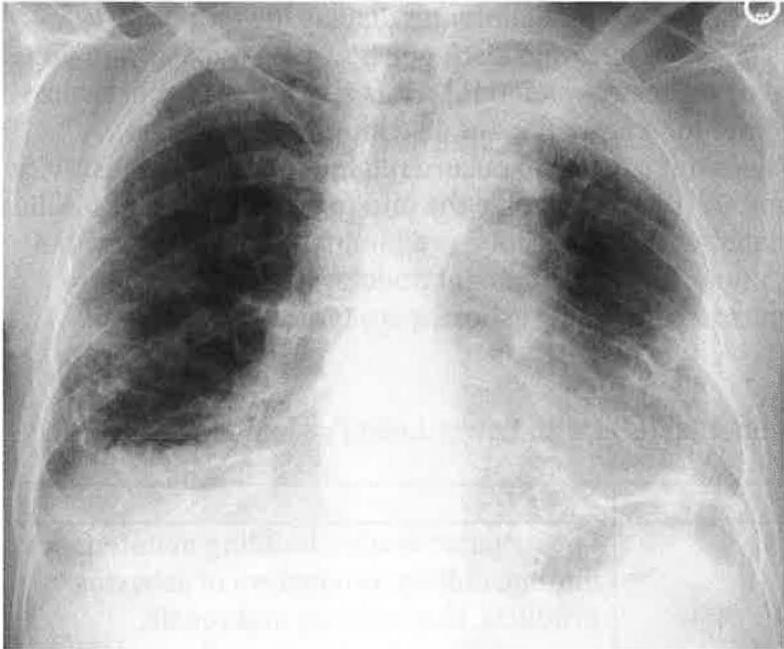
A) PA chest x-ray showing pleural and parenchymal involvement (en face plaques and diffuse pleural thickening) in a patient with a history of asbestos exposure from naval shipyards.
